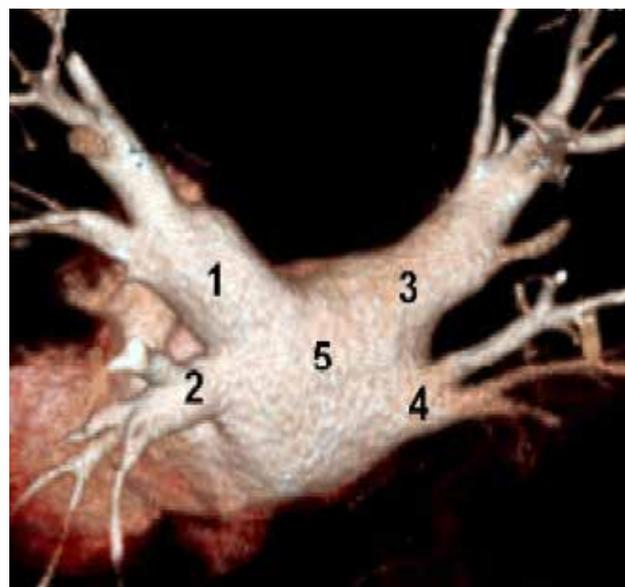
Left atrium and pulmonary veins multi-spiral computed tomographic (rear view). 1-LSPV, 2 – LIPV, 3- RSPV, 4- RIPV, 5- posterior wall of the left atrium. (LSPV - left superior pulmonary vein; LIPV – left inferior pulmonary vein; RSPV – right superior pulmonary vein; RIPV - right inferior pulmonary vein)
